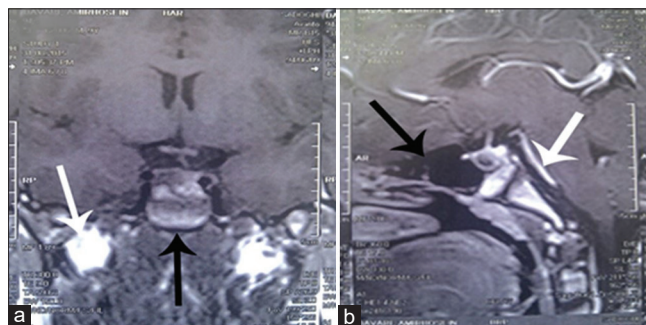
Brain magnetic resonance imaging, demonstrating a pituitary macroadenoma measuring 14 mm × 12 mm × 8 mm; (a) Coronal; white arrow refers to optic nerve without any pressure effect, black arrow shows adenoma and (b) sagittal planes; white arrow refers to basilar artery and black arrow shows empty sella tursica induced by pressure effects of adenoma
